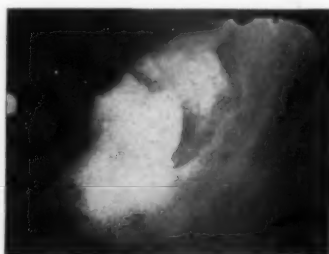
Roentgenogram of dentinoma in Case 1.
